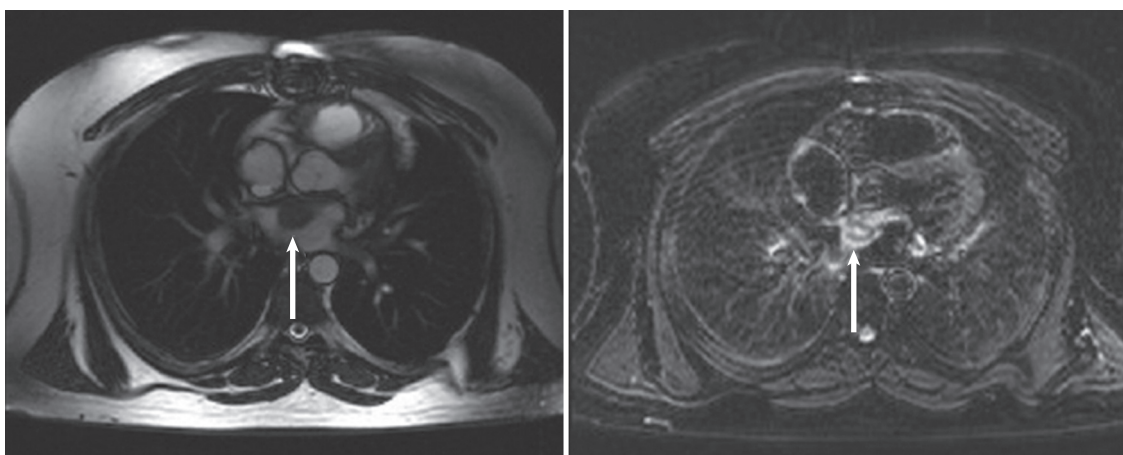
MRI of a left atrial sarcoma. A, T2-weighted image demonstrating a large left atrial mass near the anterior leaflet of the mitral valve (arrow). B, Brisk enhancement during first-pass perfusion of the mass (arrow) confirms a high degree of blood flow strongly suggestive of an angiosarcoma.
